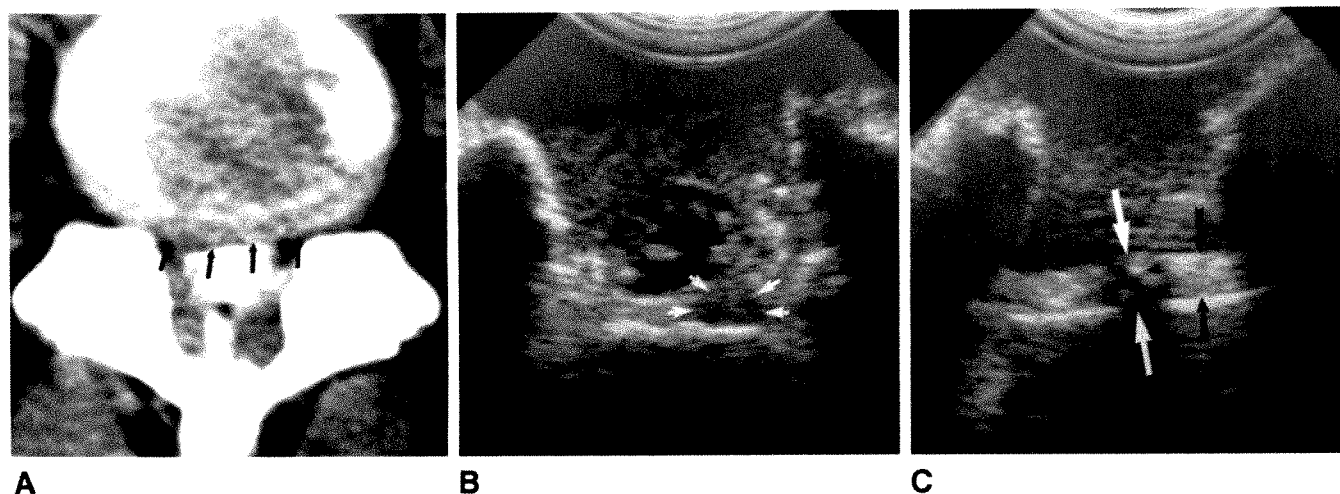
Herniated disk, shown by sonography in a patient with canal stenosis.
